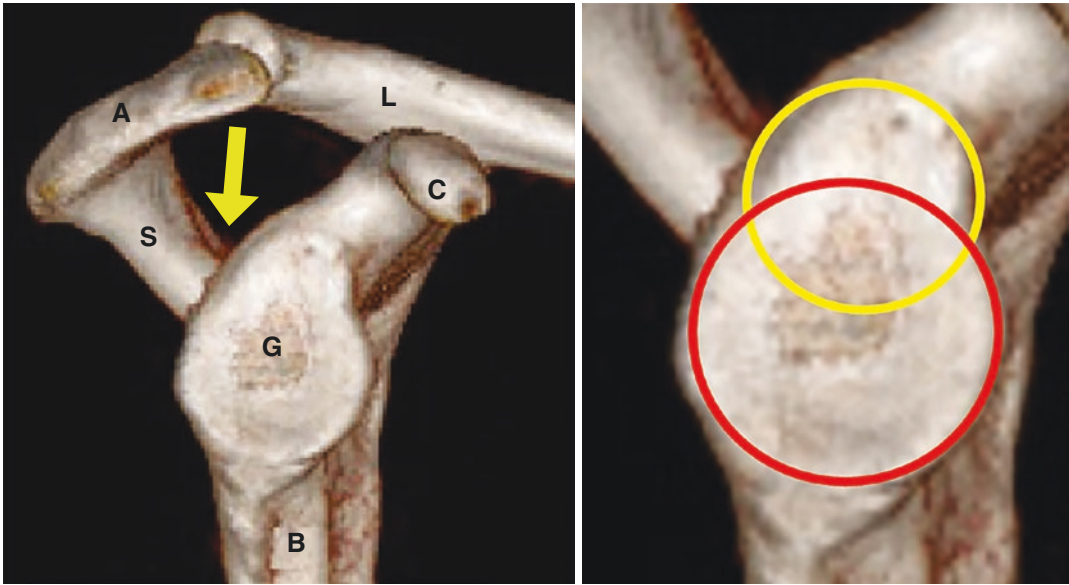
Left: 3D-CT scan of right scapula. Note the pear-shaped glenoid surface. G: Glenoid. A: Acromion. S: Scapular spine. C: Coracoid process. L: Clavicle. B: Scapular body. Yellow arrow: spinoglenoid notch. Right:
